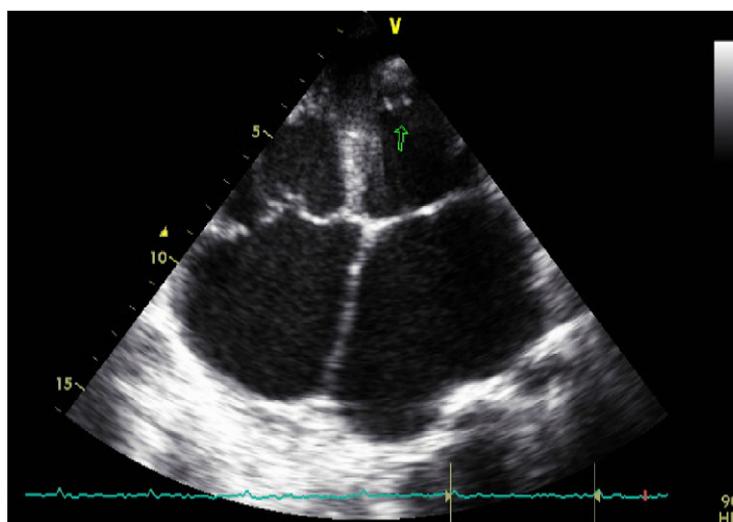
The main echocardiographic signs of bilateral endomyocardial fibrosis are seen in this photograph: small ventricles with large atria, filling defect in the apices suggesting thrombus on the left ventricle (arrow).
